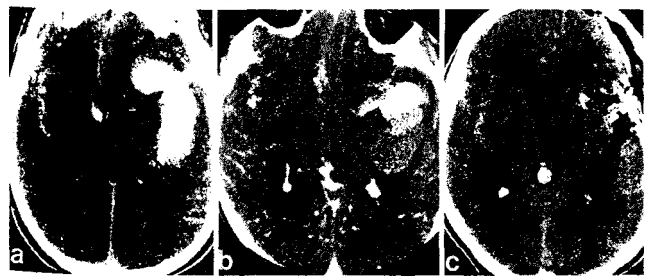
Case 19. a, Preoperative CT scan demonstrating a large left perisylvian intracerebral hematoma. b, Infusion CT scan showing a large aneurysm of the left middle cerebral artery in relation to the middle cerebral artery and branches (arrow). c, Postoperative CT scan demonstrating evacuation of the hematoma.
